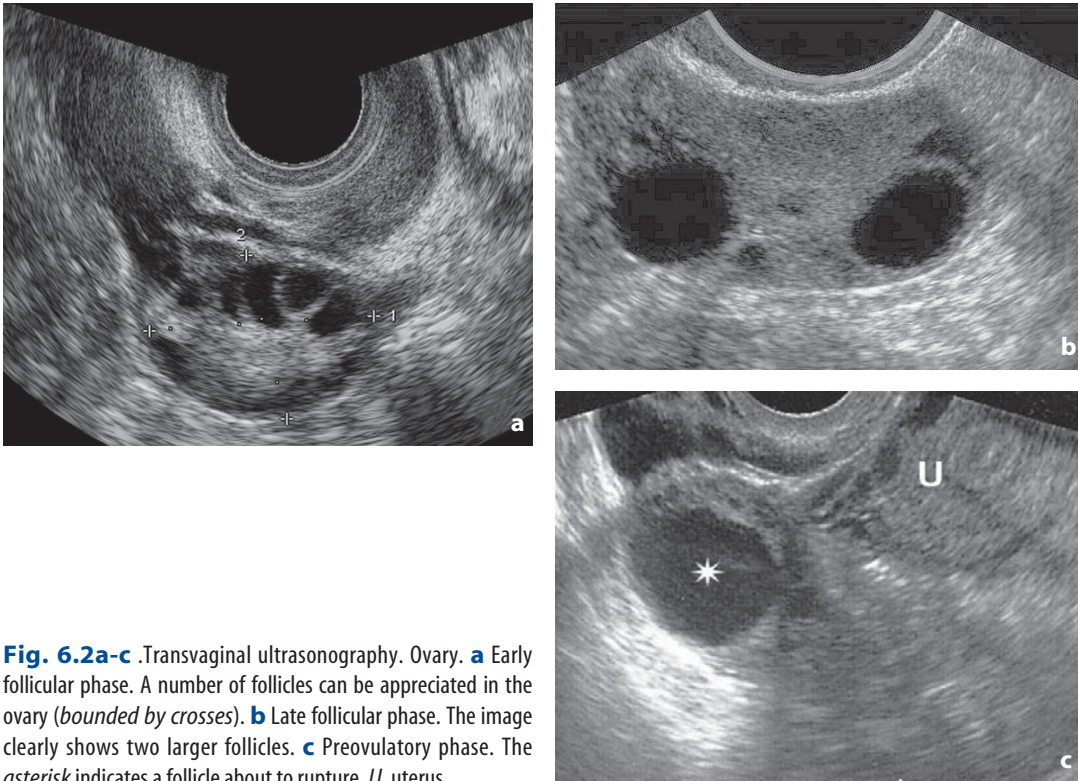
Transvaginal ultrasonography. Ovary. a Early follicular phase. A number of follicles can be appreciated in the ovary (*bounded by crosses*). b Late follicular phase. The image clearly shows two larger follicles. c Preovulatory phase. The *asterisk* indicates a follicle about to rupture. *U*, uterus
